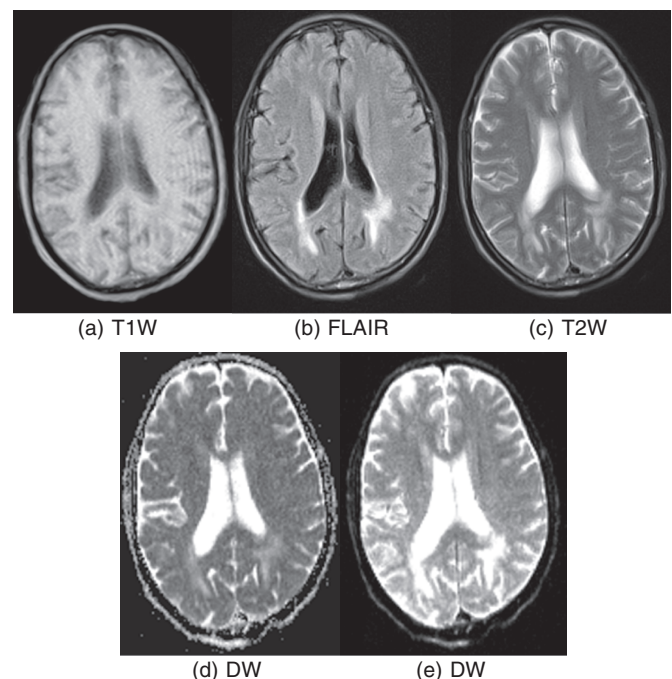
MRI scans of the brain showing bilaterally symmetrical hyperintense signal in the temporo-occipital lobes, peritrigonal white matter and centrum semiovales on T2-weighted, T2W (c) and fluid-attenuated inversion recovery, FLAIR (b) images, which appear iso- to hypo-intense on T1-weighted (T1W) images (a). No restriction of diffusion is seen in diffusion-weighted (DW) images (d and e).
